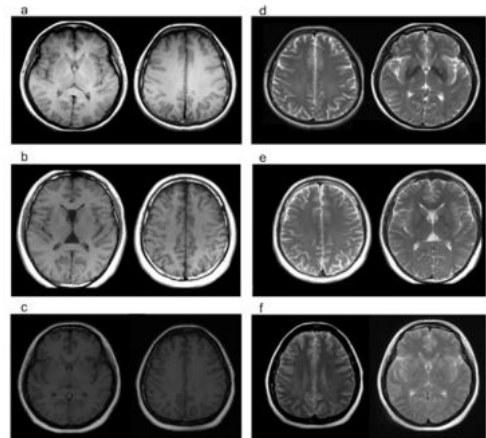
Representative T₁- and T₂-weighted images from 3T, 1.5T and 1T MRI systems. (a) T₁-weighted at 3T. (b) T₁-weighted at 1.5T. (c) T₁-weighted at 1T. (d) T₂-weighted at 3T. (e) T₂-weighted at 1.5T. (f) T₂-weighted at 1T.
